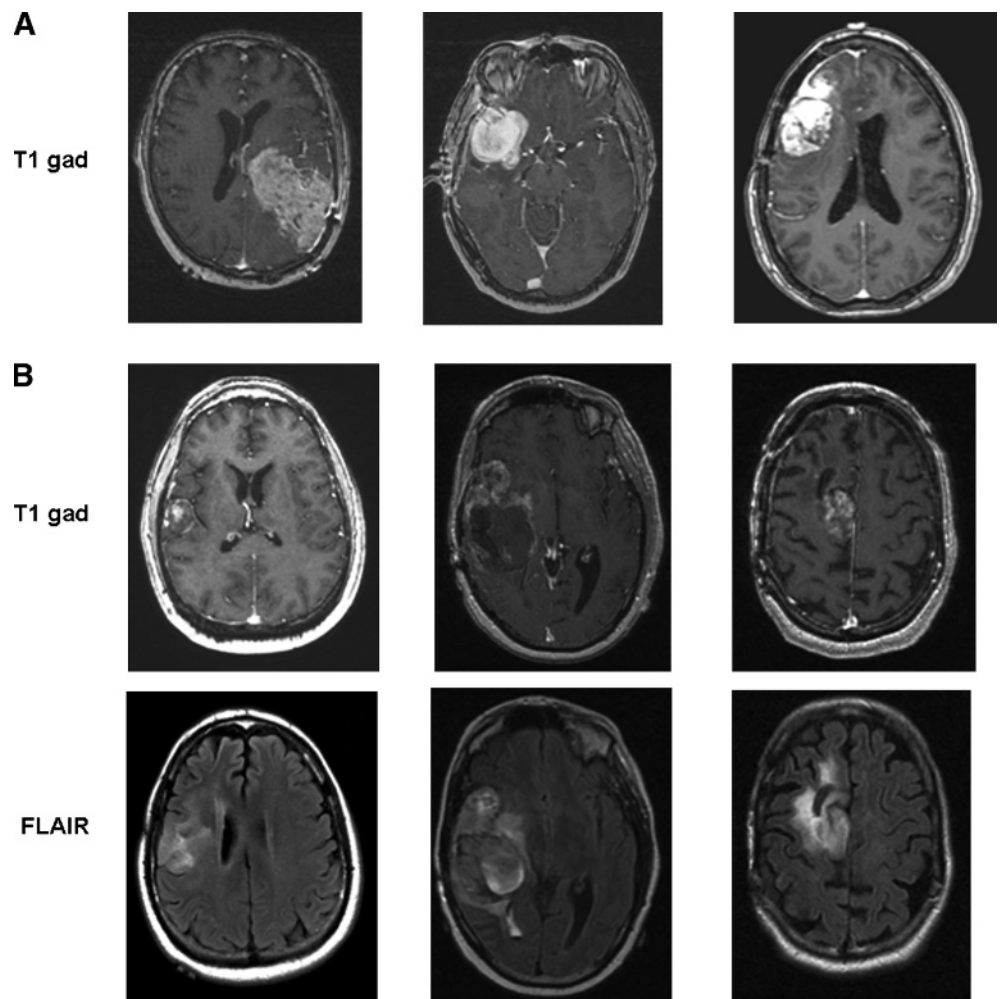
Magnetic resonance images of bevacizumab-evasive gliomas (BEGs). A, T1-gadolinium (gad)-enhanced axial images from 3 representative nodular-enhancing BEGs (NEBEGs) are shown. B, T1-gadolinium-enhanced axial images (top row) and FLAIR axial images (bottom row) from 3 representative infiltrating BEGs (IBEGs) are shown.
